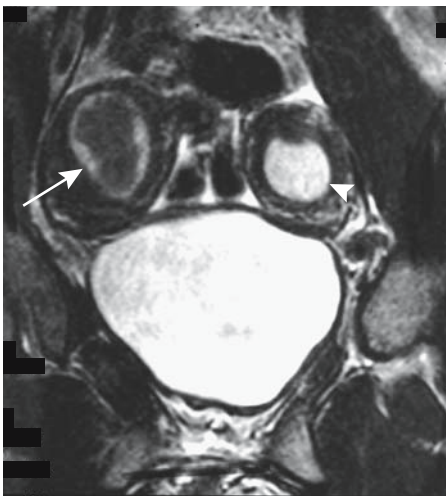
Didelphys in a 13-year-old. Right uterus (arrow) is hypointense due to blood and secretions and left uterus (arrowhead) hyperintense due to fluid and secretions. (Source: Burgener FA, Meyers SP, Tan RK, Zaunbauer W. *Differential Diagnosis in Magnetic Resonance Imaging*. Stuttgart: Thieme, 2002, with permission.)
